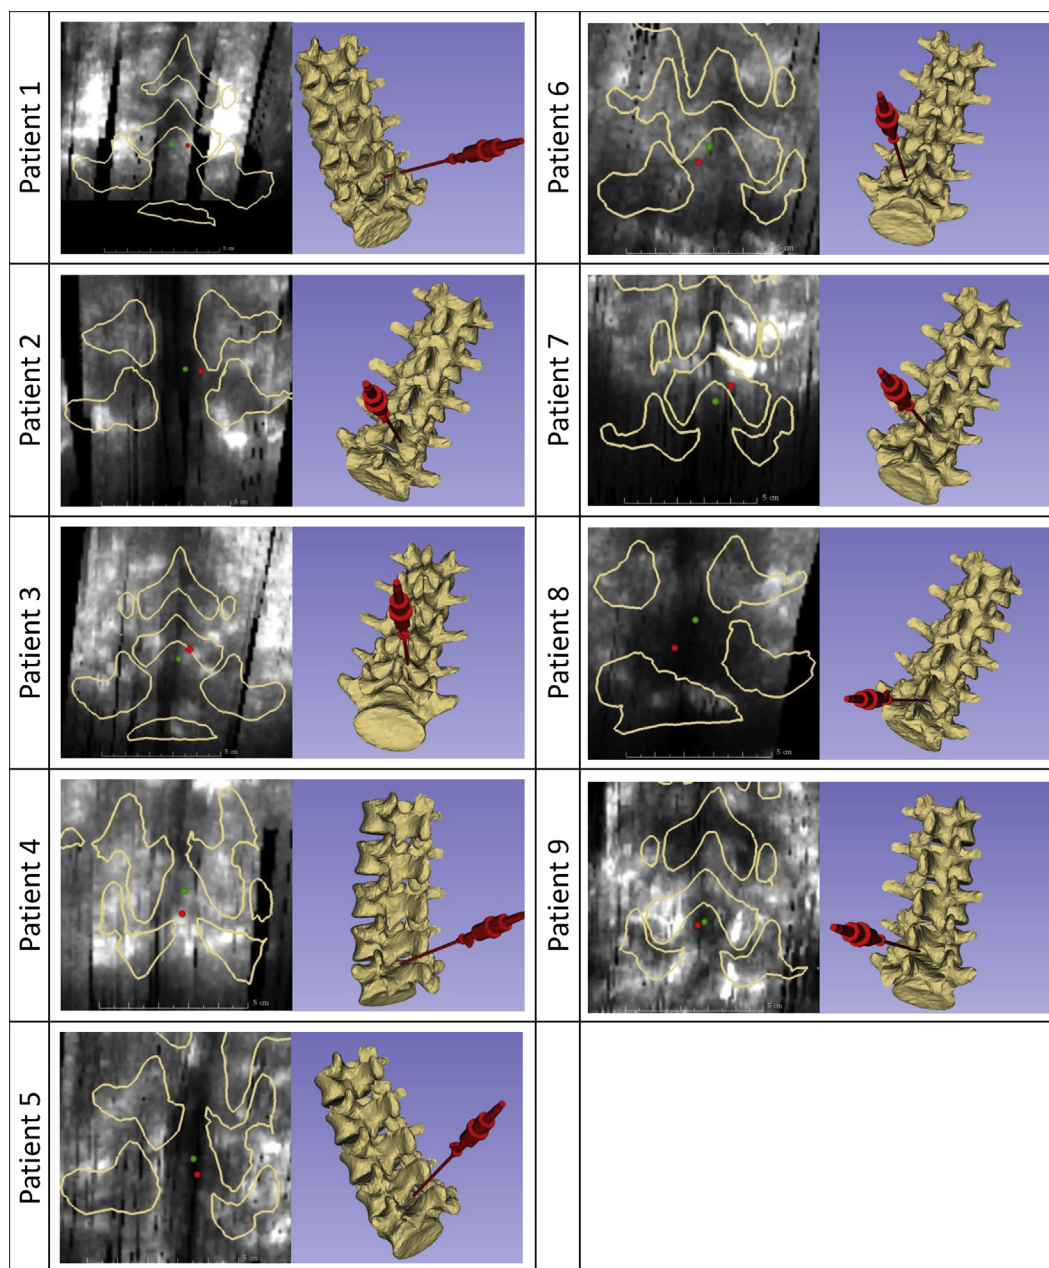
Results for epidural needle injections. For each patient, 2-D and 3-D views are visualized. In the 2-D view, the *green point* indicates the position of the epidural space as annotated by the sonographer. The ultrasound slice shown is re-formatted from the volume such that it is perpendicular to the needle vector as tracked by the electromagnetic tracking system. The *red point* indicates the intersection of the needle vector with that slice; the cut through the registered model is overlaid in beige. The 3-D view is used to visualize if the tracked needle intersects somewhere with the registered model surface (the defined measure of success).
